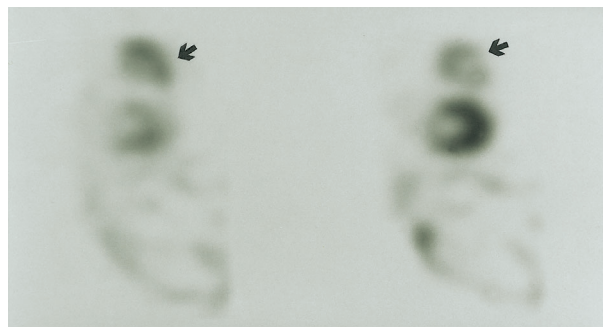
^{201}Tl SPECT coronal images showing intense focal uptake above the heart in the anterior mediastinum (black arrow).
